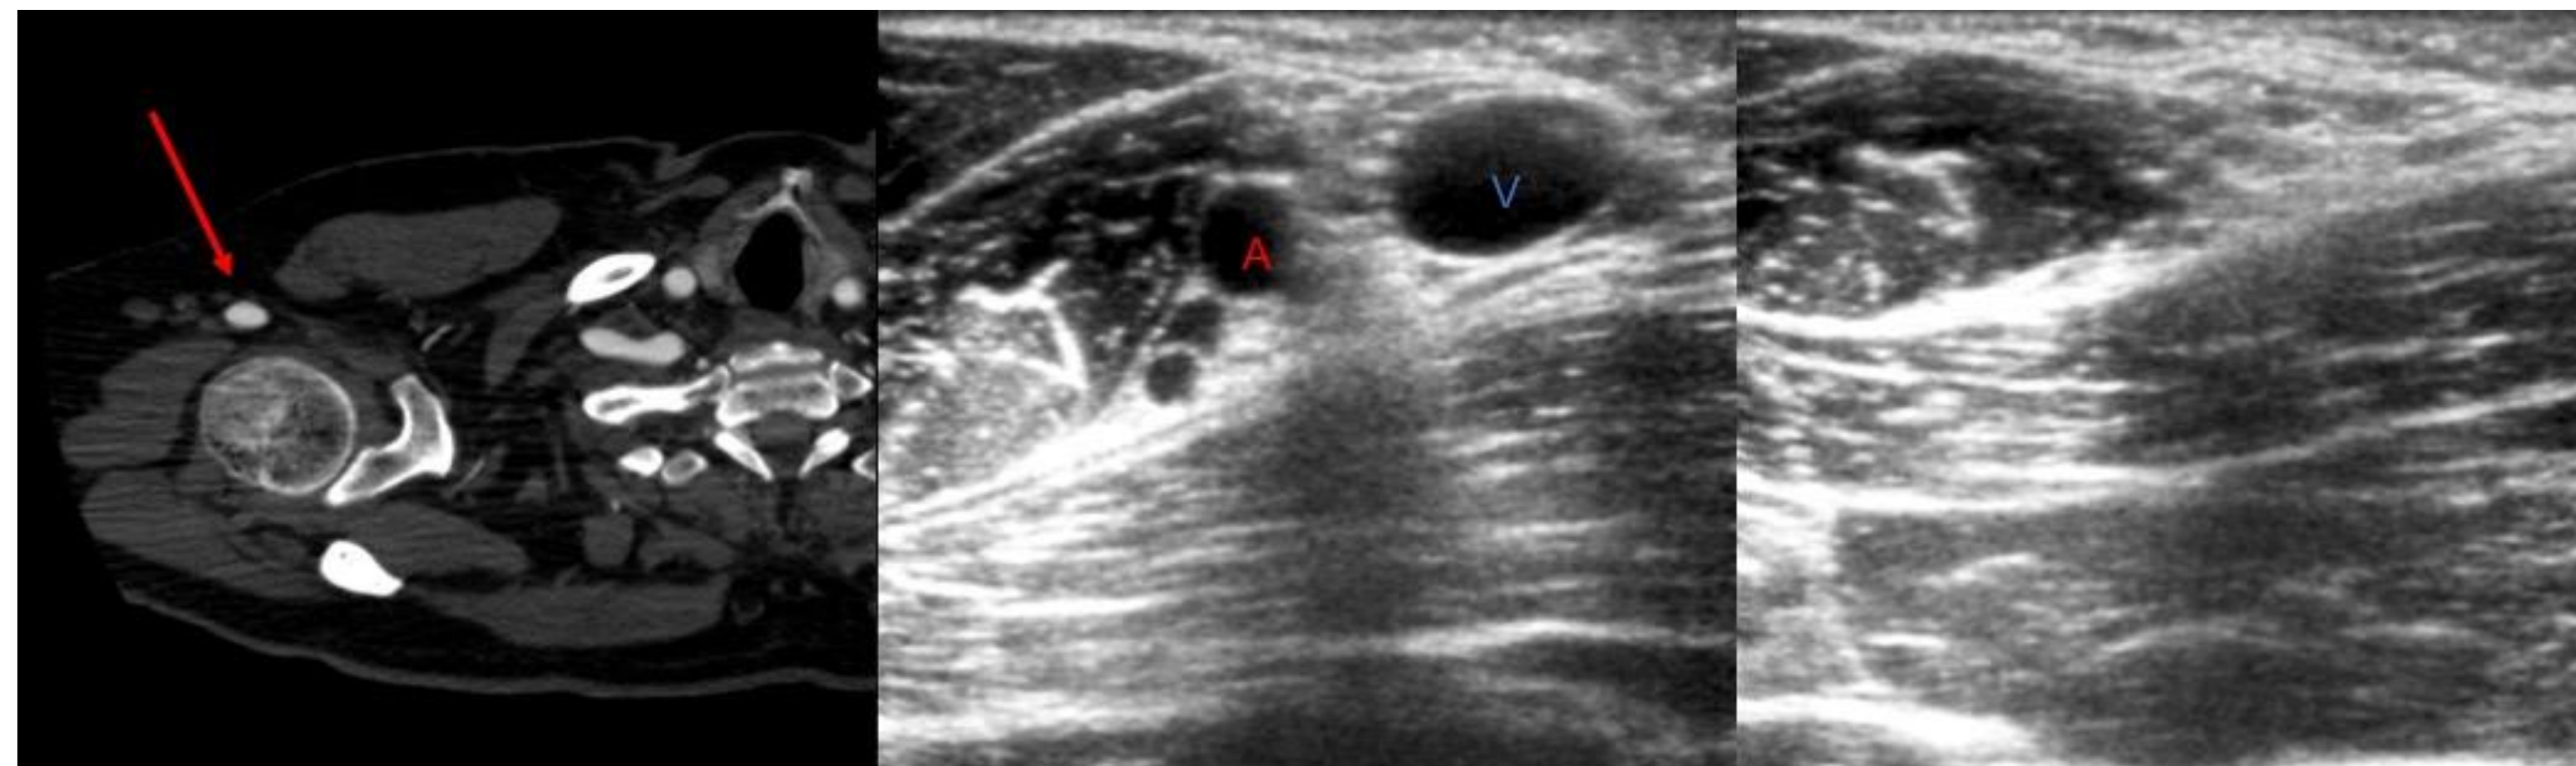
CTA of axillary artery in the delto-pectoral groove. US images of the axillary artery in the delto-pectoral groove without compression and with compression
